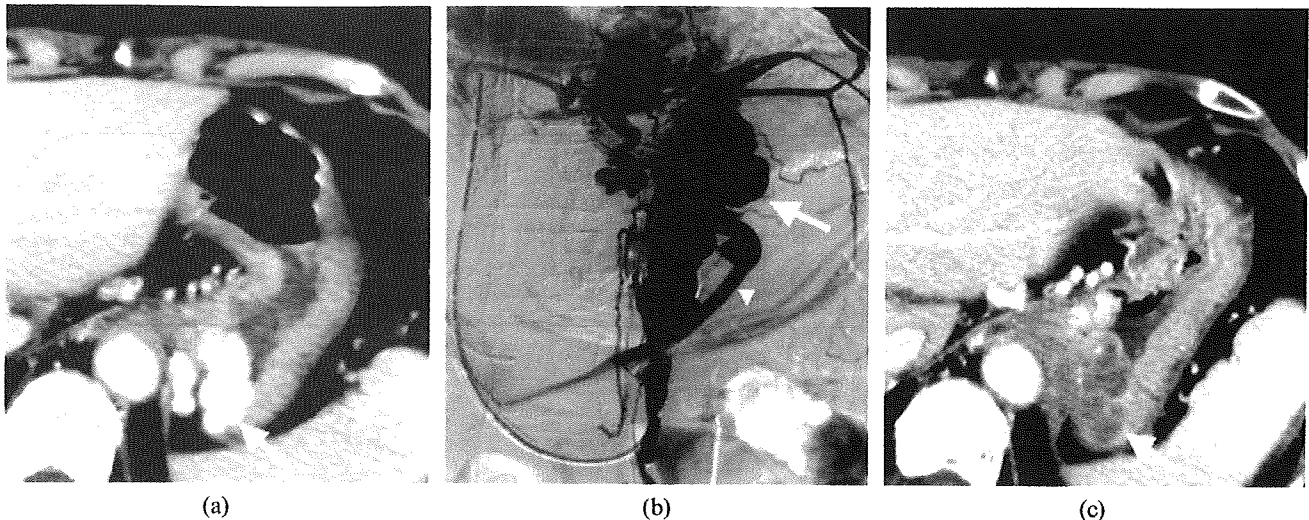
Gastric fundal varices (GV) before and after balloon-occluded retrograde transvenous obliteration (B-RTO) in a 72-year-old woman with chronic hepatitis (cryptogenic). (a) Contrast-enhanced CT before B-RTO showing the GV (arrow); (b) retrograde venography from a gastrorenal shunt showing the GV (arrow) and short gastric vein (SGV; arrowhead); (c) contrast-enhanced CT after B-RTO (contrast enhancement was not observed at the variceal site (arrow)). This case was completely treated by the initial B-RTO. Diameter, flow velocity and flow volume of the SGV on Doppler ultrasound were 6.9 mm, 6.3 cm s⁻¹ and 140 ml min⁻¹, respectively.
